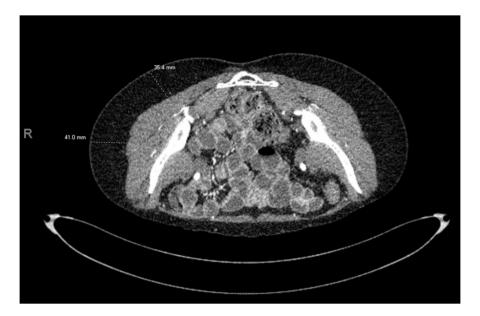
CTA demonstrating adequate available soft tissue donor in buttock compared to abdomen on a lean patient. CTA: Computed tomography angiography.
